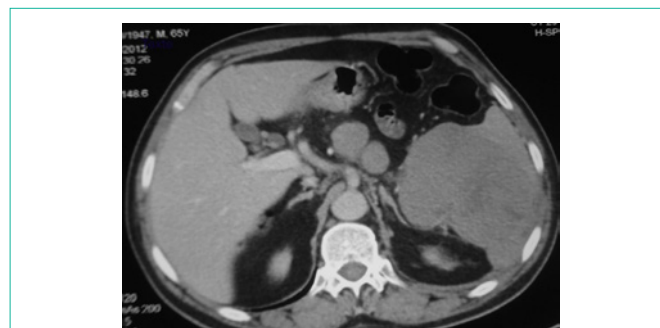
Computed tomography of the abdomen shows an enlarged spleen with multiple irregular and attenuated density lesions, perisplenic lymphadenopathy, around the pancreatic tail and splenic hilum.
